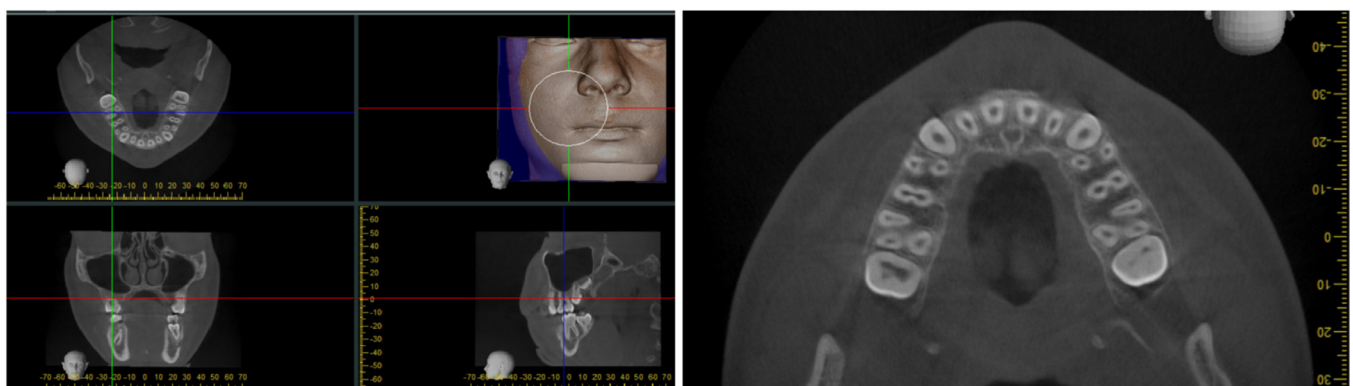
(A) CBCT image, (B) orientation using the axial section.
